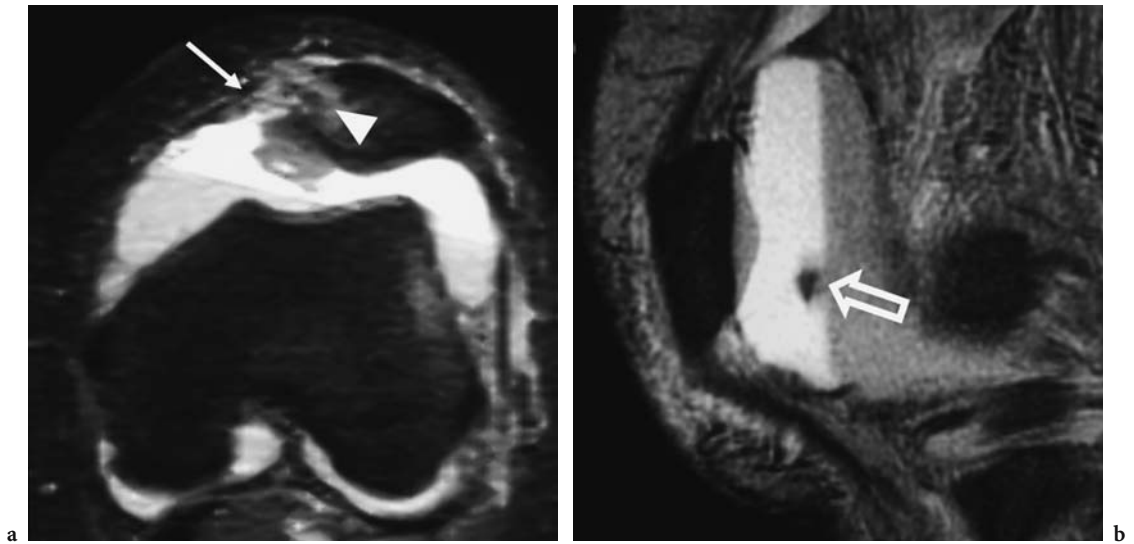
Acute patellar dislocation. a Proton density fat suppression axial; b Sagittal T2 gradient echo MR image showing tear of the medial retinaculum (*arrow*), high signal in the anterolateral aspect of the lateral femoral condyle and medial aspect of the patella (*arrowhead*) and patellar osteochondral fracture floating on fluid/fluid level (*open arrow*)
